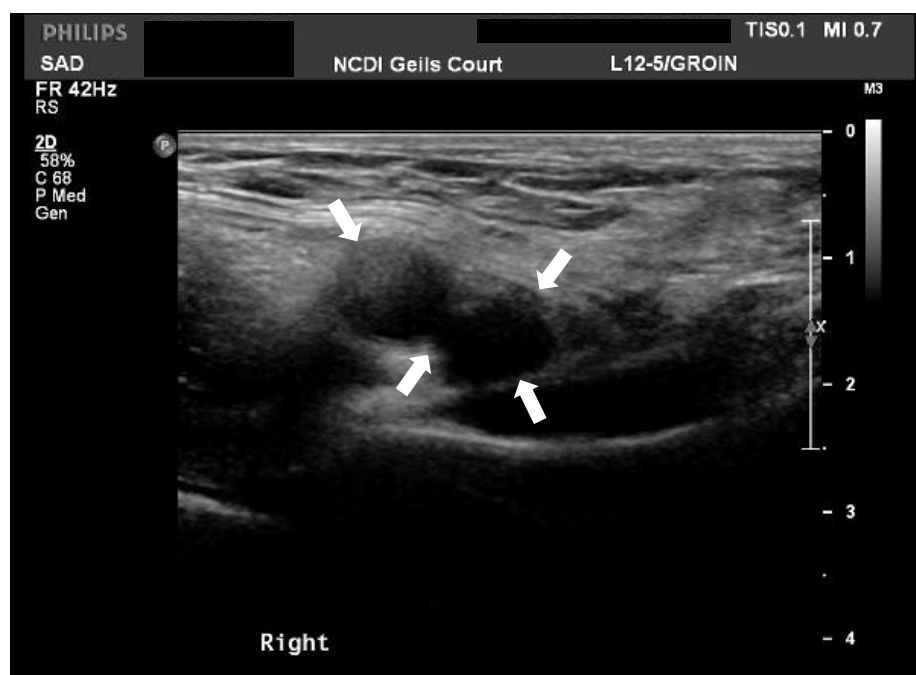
Ultrasound image showing a tender, bilobed hypodense lesion in the right inguinal canal.
